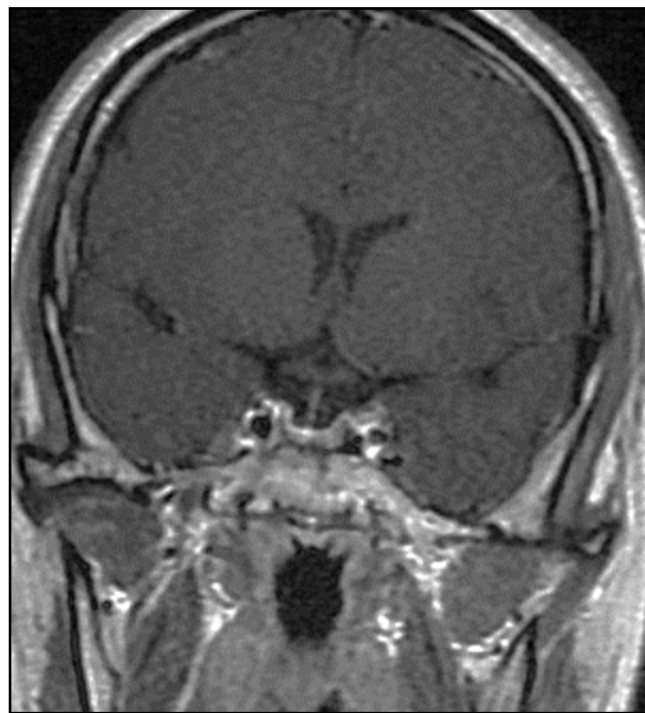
MRI showing complete removal of pituitary microadenoma
